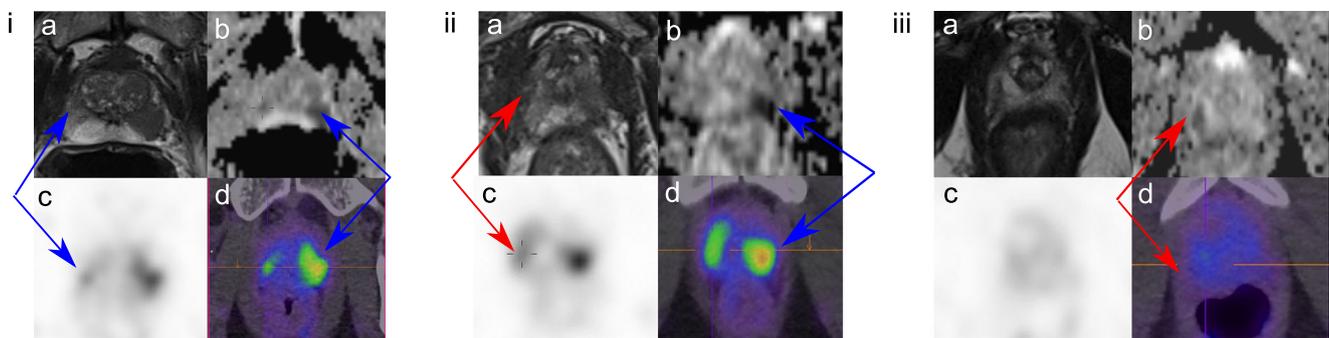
Comparative imaging from three patients (i – iii) that demonstrate suspicious lesions seen on both mpMRI and ^{68}Ga -PSMA PET/CT (i), multifocal disease seen with ^{68}Ga -PSMA PET/CT and not mpMRI (ii) and index lesion seen on mpMRI but not convincingly detected on ^{68}Ga -PSMA PET/CT (iii). a - axial T2 weighted image; b - apparent diffusion
